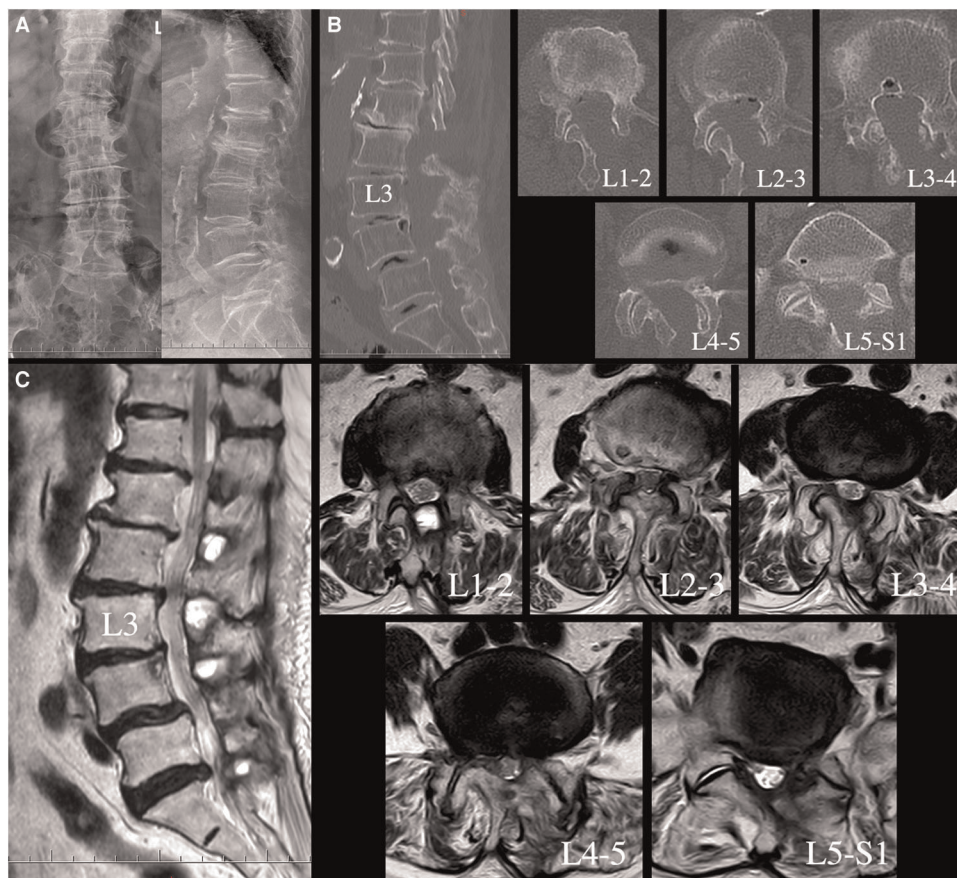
The lumbar X-ray radiograph of 1-year follow-up demonstrating all surgical segments remained stable (A). Lumbar CT of 1-year follow-up showing the bony structure changes of surgical segments (B). Sagittal and axial T2-weighted lumbar MRI revealing satisfactory decompression of lumbar canal from L1-2 to L5-S1 (C).
